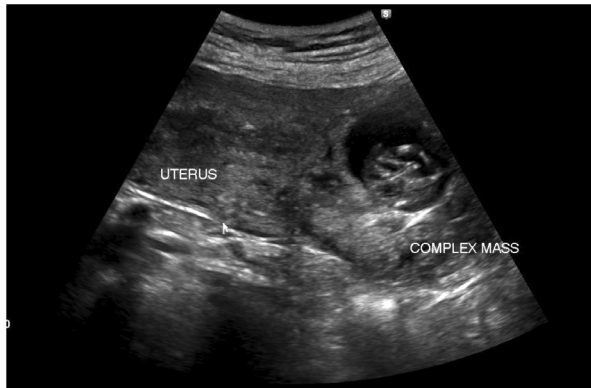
Transabdominal sagittal ultrasound scan showing the previously seen complex mass is enlarging and seen at the left anterior lower uterine segment.
